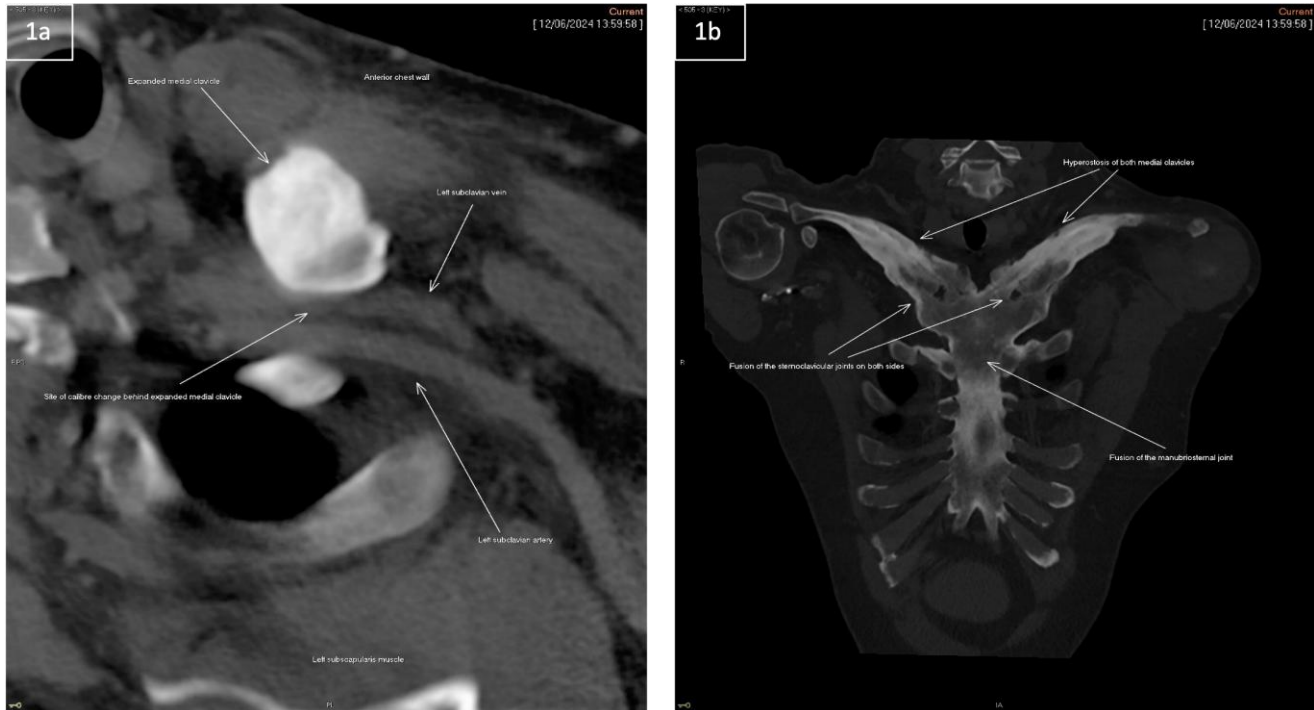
Axial Contrast-Enhanced CT of the Thoracic Outlet shows expansile cortical overgrowth of the left medial clavicle, compressing the left subclavian vein, resulting in a caliber change indicative of venous obstruction. Figure 1b Coronal CT image reveals bilateral clavicular hyperostosis, with fusion of the sternoclavicular joints and sclerosis of the manubriosternal joint, indicative of CNO.
